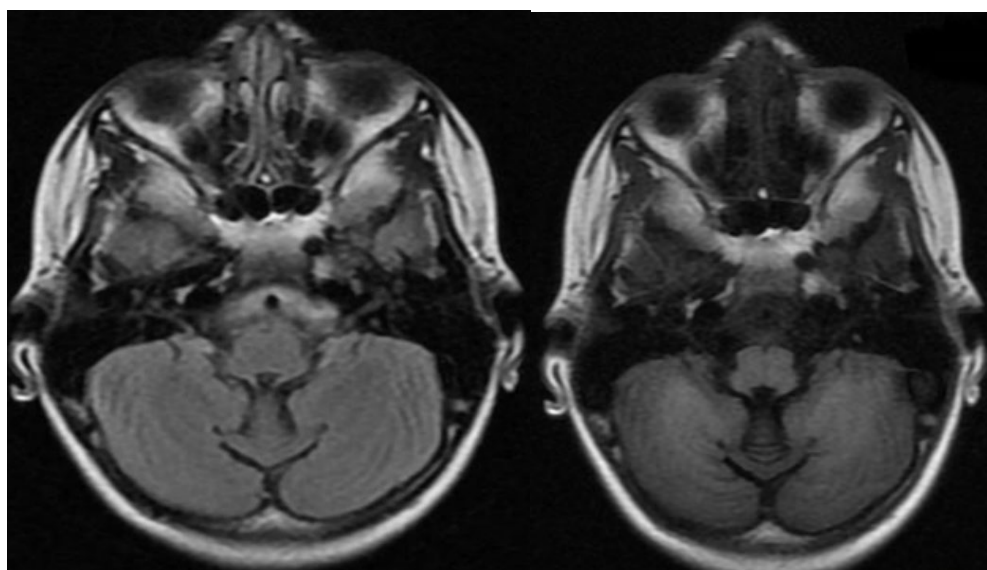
FLAIR and T1-Weighted FLAIR Axial Sections: No Significant Volumetric Reduction of the Cerebellum (white arrows).
